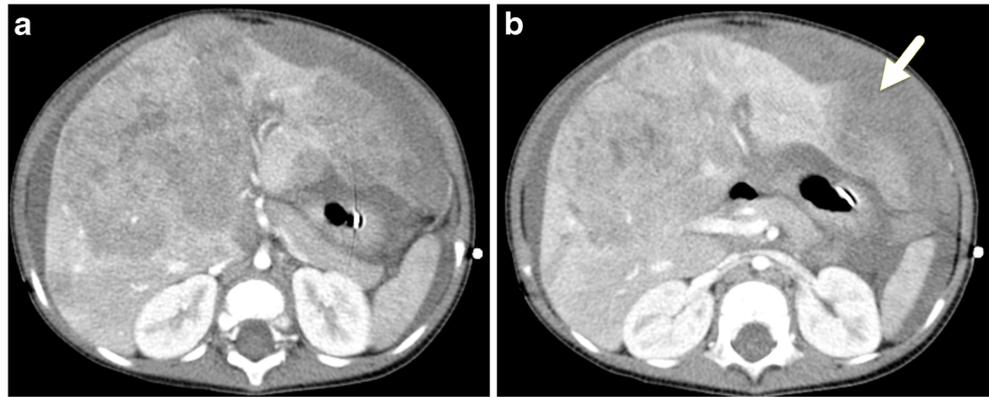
Tumor rupture. Axial contrast-enhanced CT images in a child with hepatoblastoma show tumor rupture. In (a), the tumor capsule is contiguous. In (b), there is a defect (arrow) in the tumor capsule. The fluid adjacent to the liver measures 33 Hounsfield units
